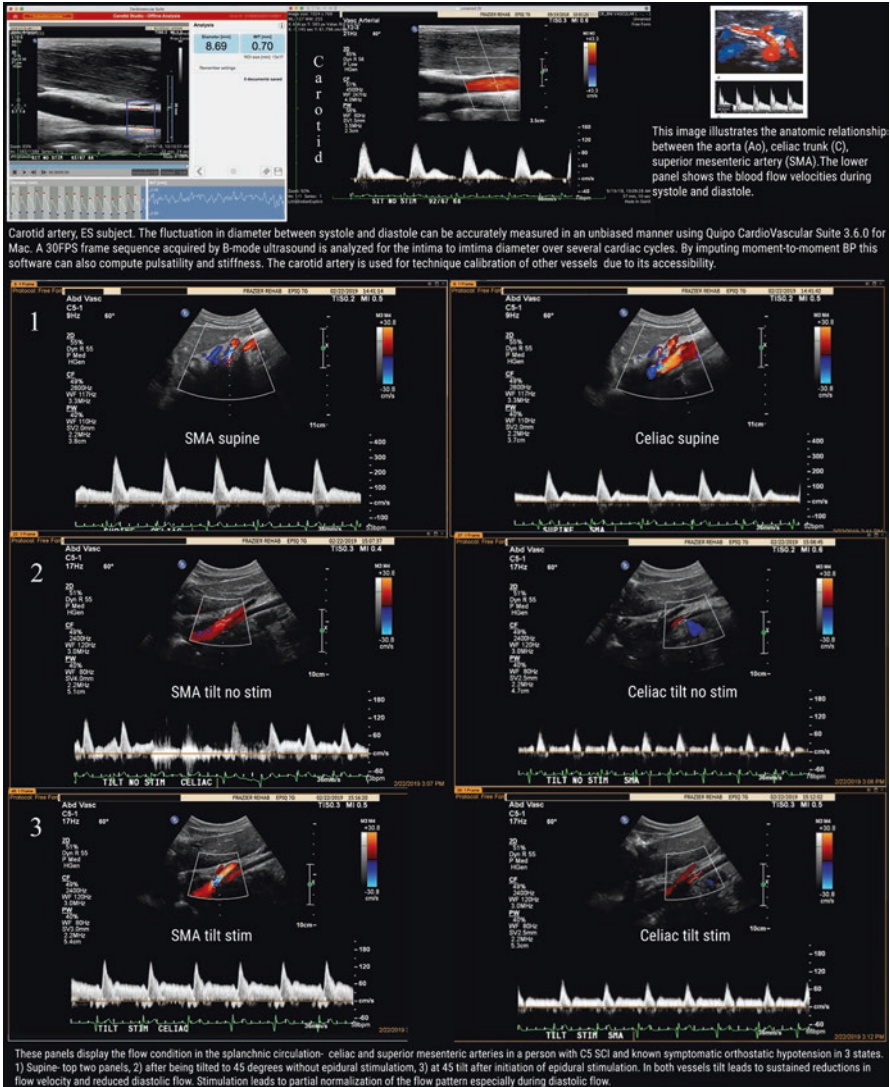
Epidural stimulation is shown to improve blood flow in a tetraplegic with severe postural hypotension during a 70° tilt. Shown are color flow and velocity ultrasound measurements with peak waveforms during systole followed by the diastolic phase. The upper panel shows the carotid artery, images on the left indicate the change in intimal diameter during several cardiac cycles quantified in Carotid Studio, Quipo Software, Pisa, Italy. Lower panels show the Doppler signal recorded from the superior mesenteric (SMA) and celiac arteries in (1) Supine, (2) Tilt without ES stimulation and (3) Tilt with ES stimulation with breathing held during insonation. In the tilt, no-stim state, the diastolic Phase is collapsed. When stimulation is initiated, the diastolic flow is recovered
